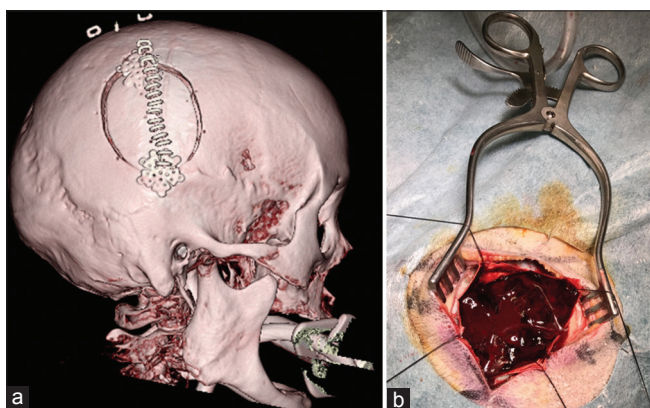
(a) Three-dimensional computed tomography shows the cranial bone after the procedure. An approximately 8-cm linear skin incision was made parallel to the coronal suture, and small craniotomy of 5–6 cm in diameter was made on the point under which the hematoma thickness was largest. (b) Small craniotomy was performed at the thickest point of the hematoma to insert the endoscope.
